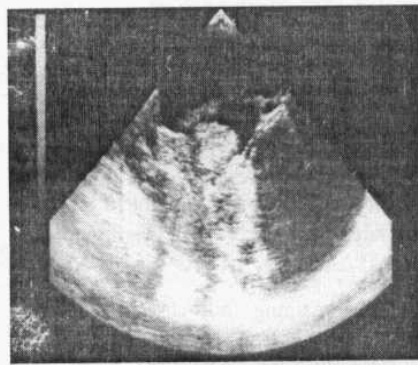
Multiple hydatid cyst of the liver as seen by CT and US.
